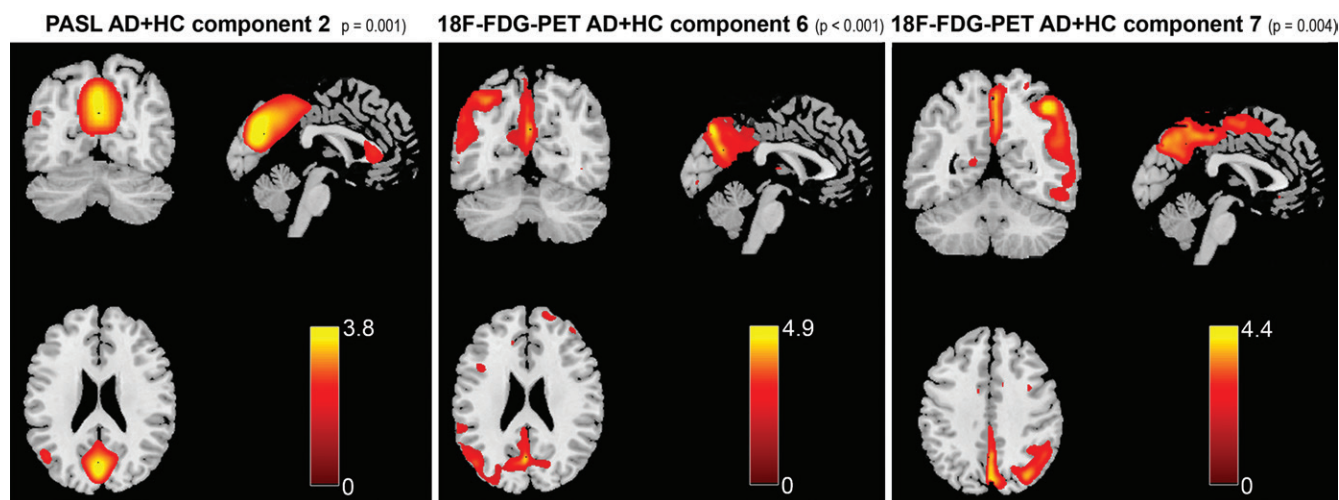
Exemplary views (threshold, $|Z| > 2$) of significant components involving the precuneus and posterior cingulate for patients with Alzheimer disease (AD) and healthy control (HC) participants by using pulsed ASL (left) and fluorine 18 (^{18}F) fluorodeoxyglucose (FDG) PET (middle and right). The component number and P values resulting from the independent component analysis source-based morphometry statistical analyses are in Tables E1 and E2 (online).
